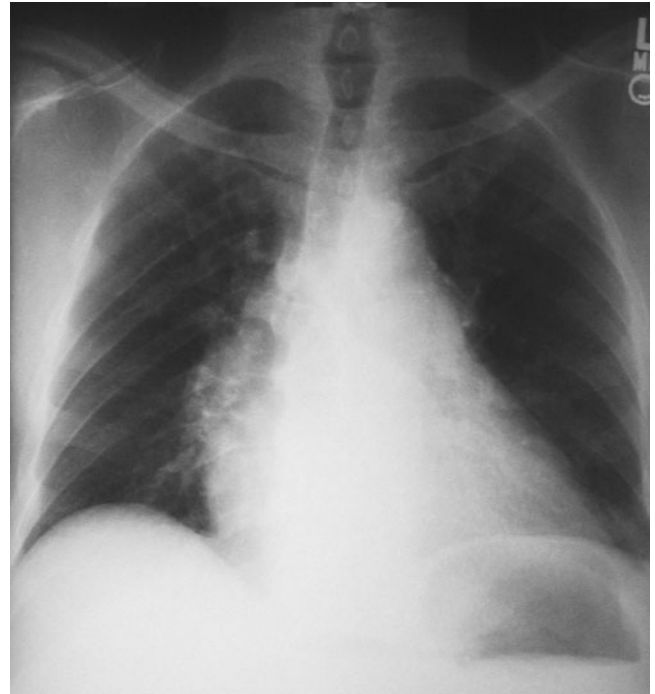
Chest radiograph of a patient with chronic thromboembolic pulmonary disease and evidence of pulmonary hypertension. Note the enlarged right atrium and right ventricle, disparity of size between the left and right pulmonary arteries, and the hypoperfusion in several areas of the lung fields.
